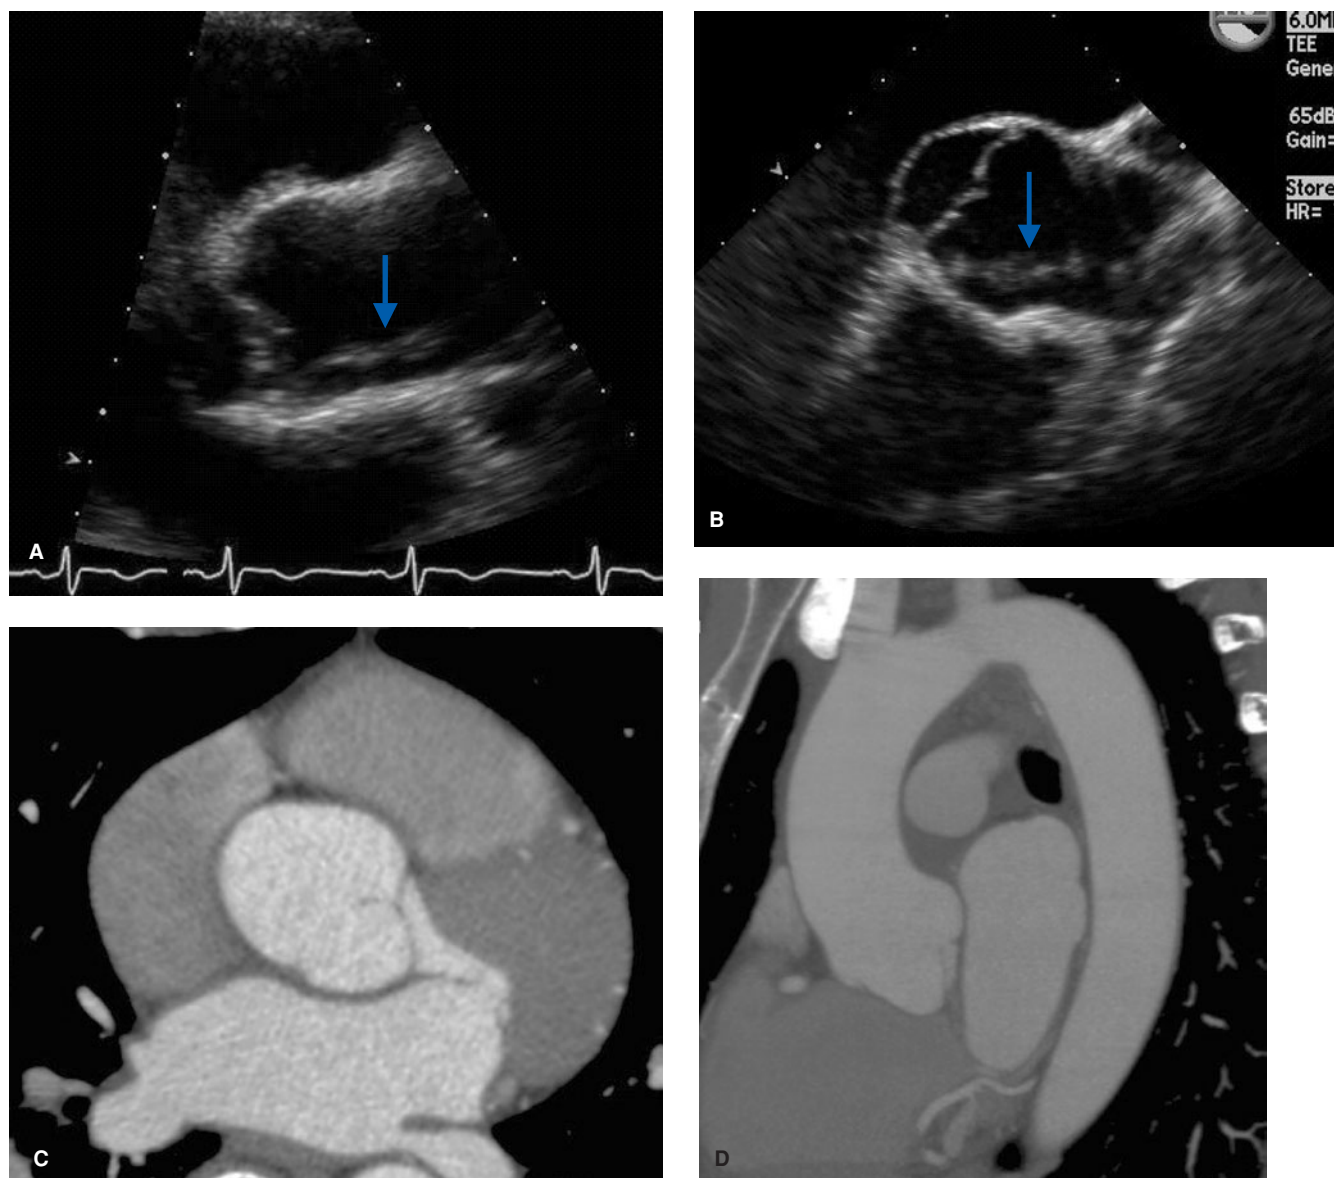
Although multiple modalities may be used for evaluation of the aortic root, with recent technical advances, cardiac CT is the “gold standard” for the exclusion of type A dissection. Parasternal long-axis image from transthoracic echocardiogram (A) demonstrates a linear area of echogenicity (white arrow) above the noncoronary cusp of the aortic valve, concerning for an intimal flap. The finding was detected incidentally in a patient with recent stroke and possible patent foramen ovale. Subsequent transesophageal echocardiogram (B) again demonstrates the finding. Axial image from cardiac CT scan (C) provides excellent visualization of the aortic root and excludes the presence of an intimal flap. Sagittal oblique maximum-intensity projection image (D) shows the aortic root and ascending aorta to be normal. Echocardiographic findings were presumed to be due to artifact.
